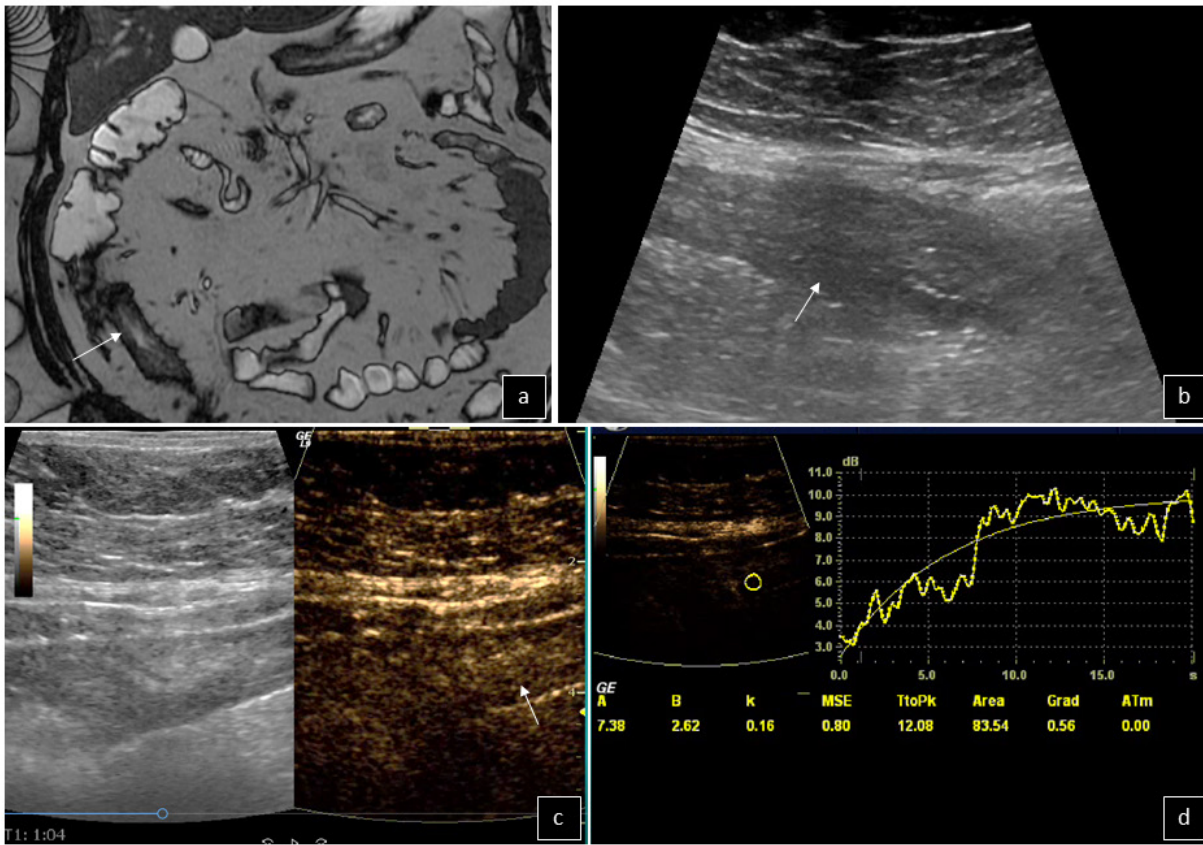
Crohn's disease: Thickened terminal ileus wall is noted on MRI (arrow in a) and on B-mode US (arrow in b). On CEUS the wall shows increased enhancement (arrow in c). Quantitative measurement of bowel wall vascularity is consistent with increased inflammatory activity (d).
